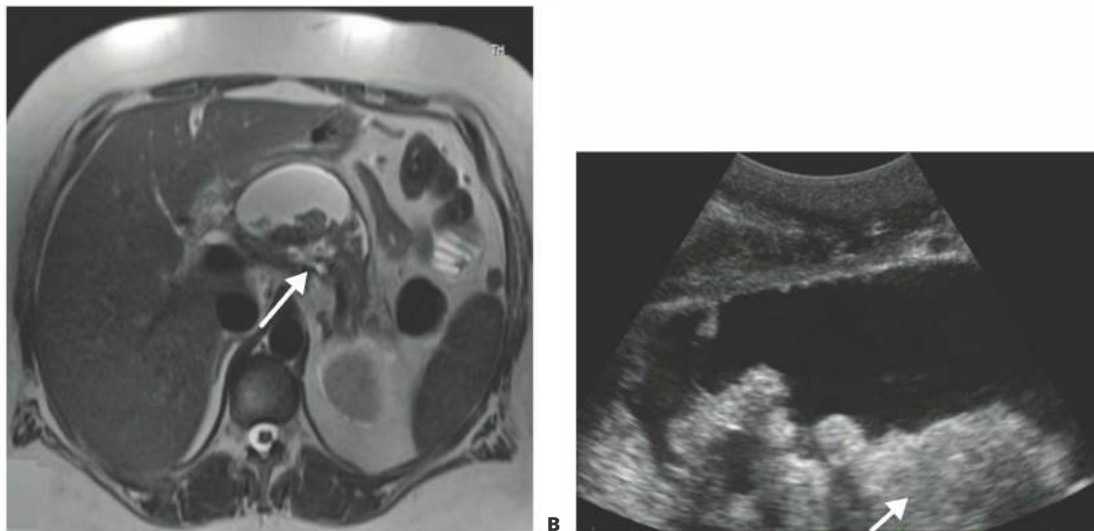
• A. MRI showing solid and fluid components (*arrow*) of peripancreatic collections. B. IOUS image of the same collection. Solid necrosis is highlighted with *arrow*.
